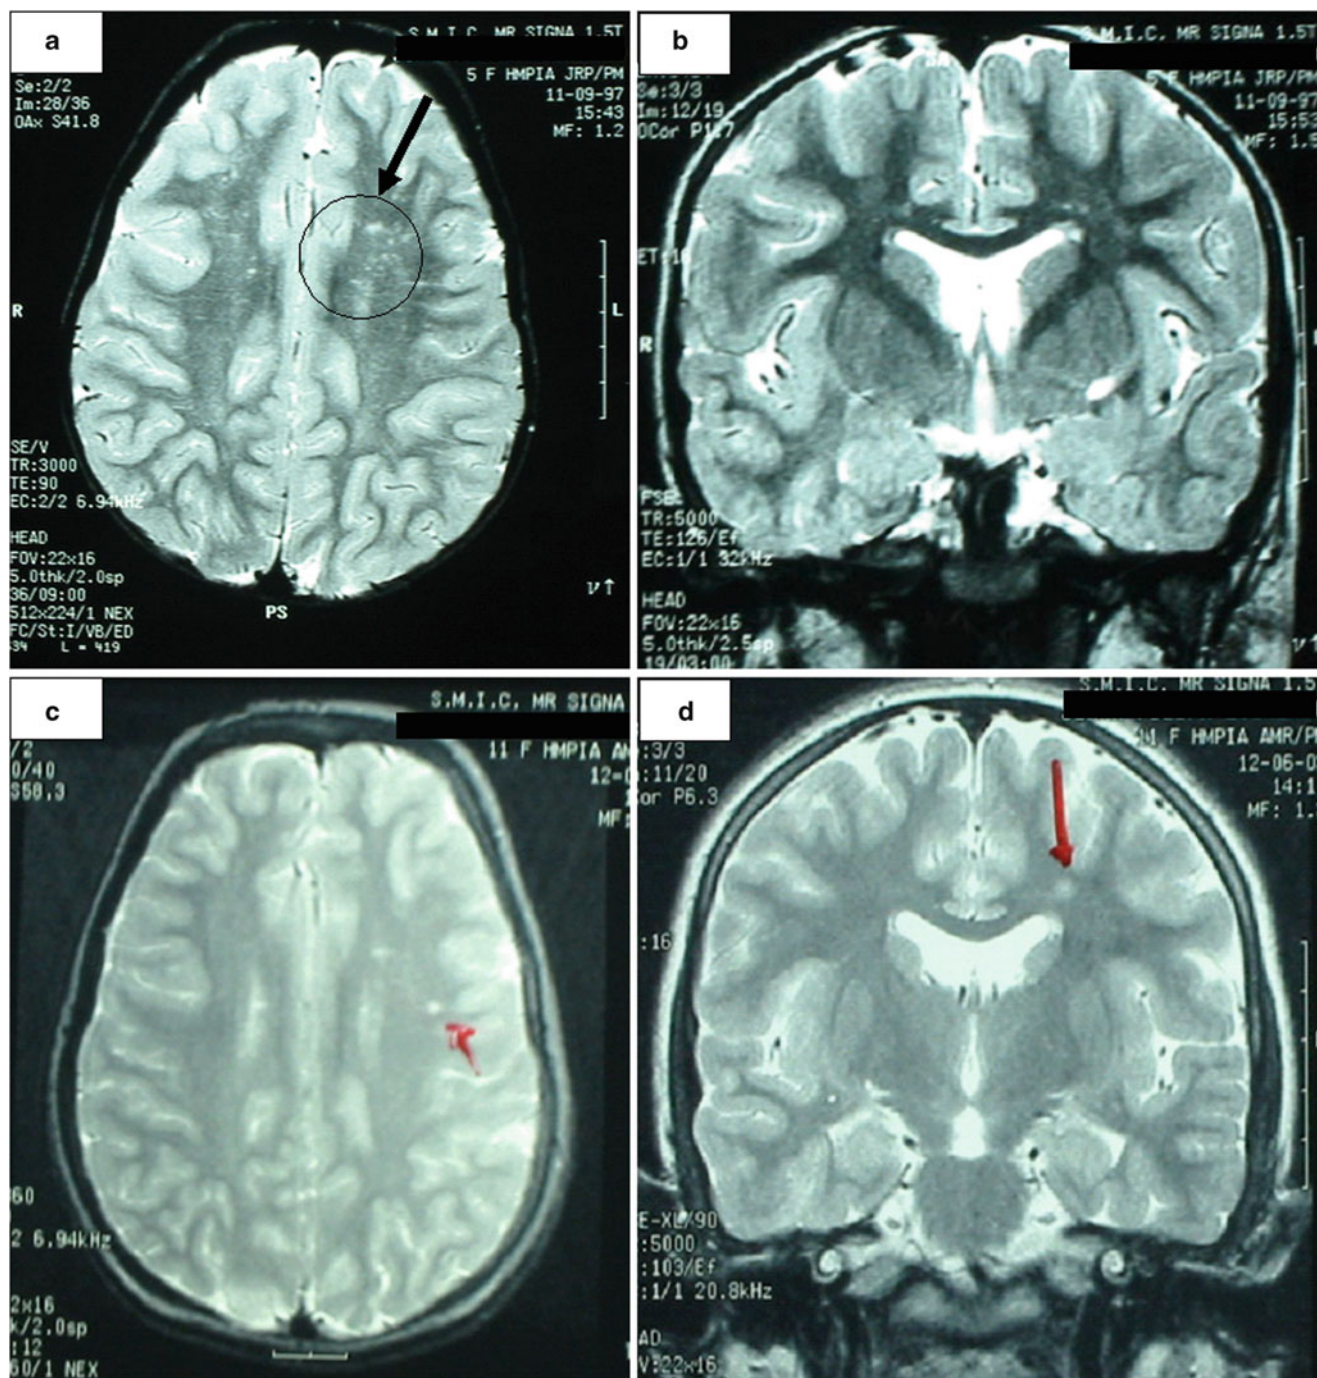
Brain MRI studies in Patient 1. Before OLT we detected (a) an increased T2 signal intensity within the peritrigonal white matter (black circle and arrow) and (b) increased T2 signal intensity within the semioval center, more prominent in the left hemisphere.
